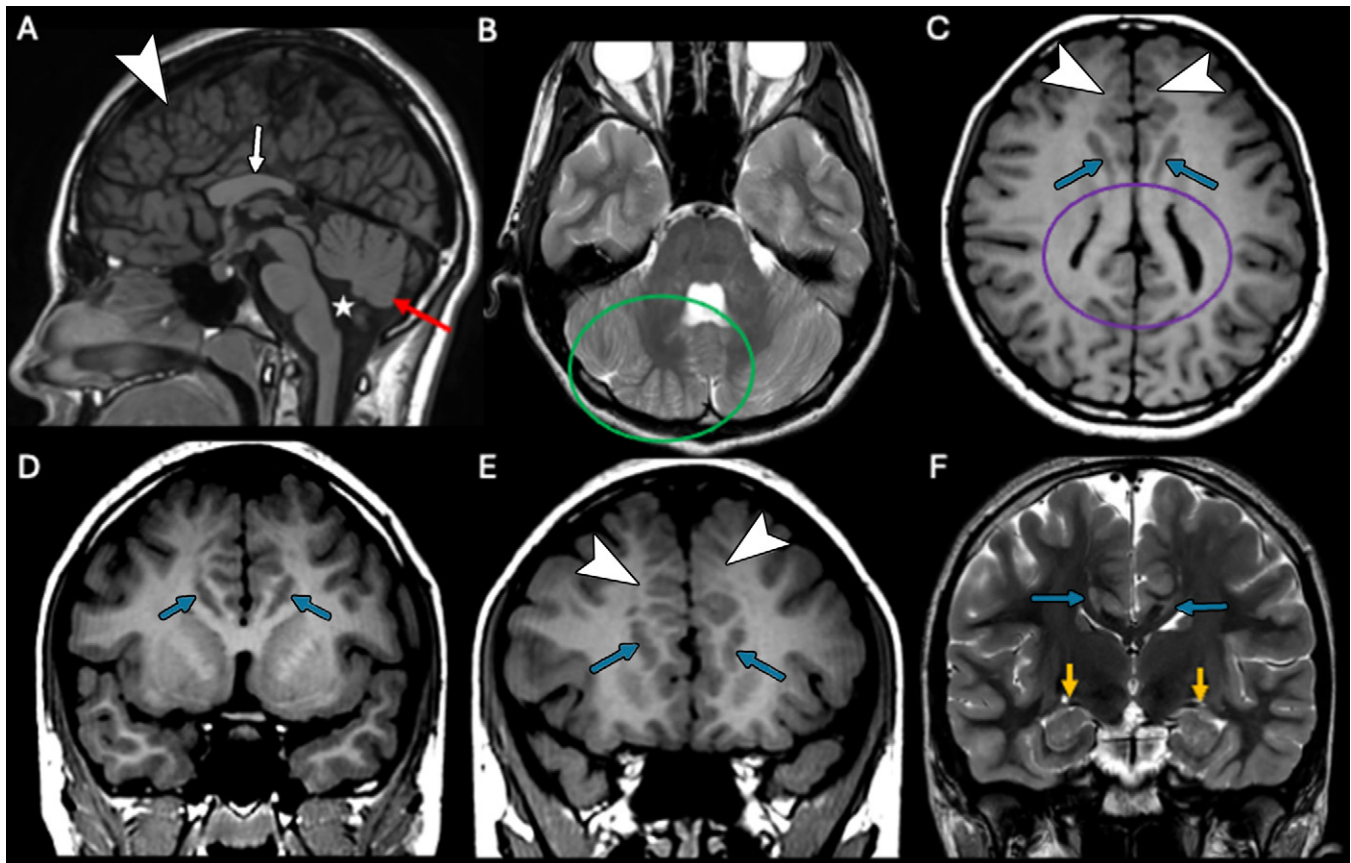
Brain MRI shows various findings suggestive of Chudley-McCullough syndrome. (A) Sagittal midline T1-weighted image shows hypoplasia and dysgenesis of the corpus callosum (white arrow), which is short and dysmorphic, with no identifiable splenium or genu, as well as hypoplasia of the inferior vermis (red arrow) with an elevated 38° tectovermian angle (star). (B) Axial T2-weighted image of the posterior fossa depicts right cerebellar dysplasia (green circle). (C–E) Extensive areas of frontal mesial polymicrogyria (arrowheads) are observed on T1-weighted axial (C) and coronal (D, E) images, as well as bilateral and symmetrical frontal subcortical heterotopias, with a distinctive comma-like appearance (blue arrows). The lateral ventricles are asymmetrically enlarged with a colpocephalic shape (C, purple circle). (F) Coronal T2-weighted image shows bilateral malrotated hippocampi (yellow arrows).
